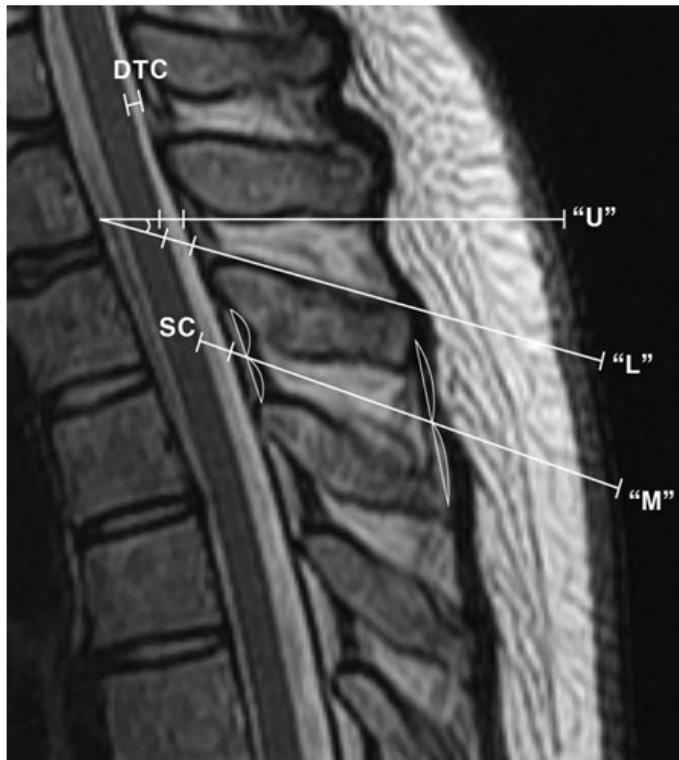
Dimensions on three approaching lines and the angle between the "U" and "L" lines on MRI
